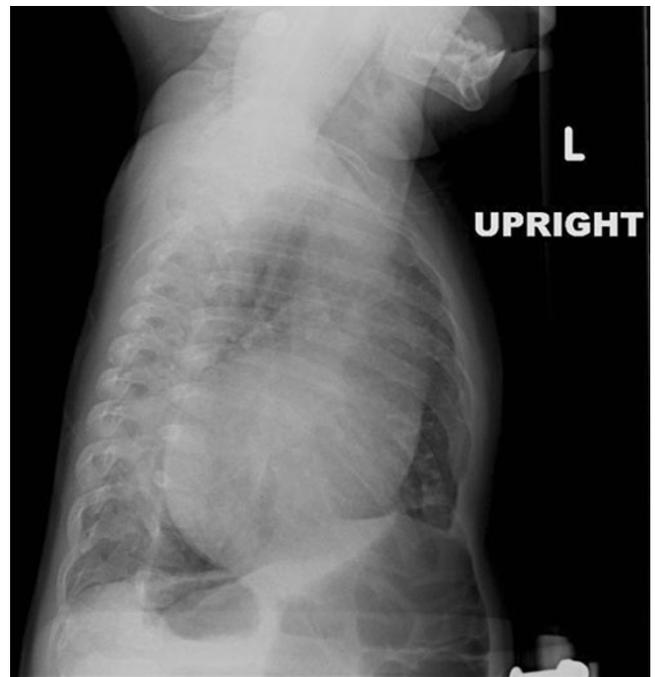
Lateral chest X-ray showing cardiomegaly
